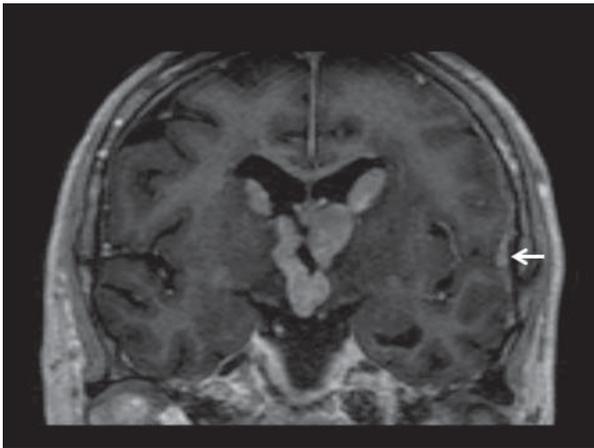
Post-gadolinium coronal MR image showing intraventricular masses extending through Foramen of Monro bilaterally into the third ventricle as well as leptomeningeal thickening in the left temporo-parietal region (arrow).
